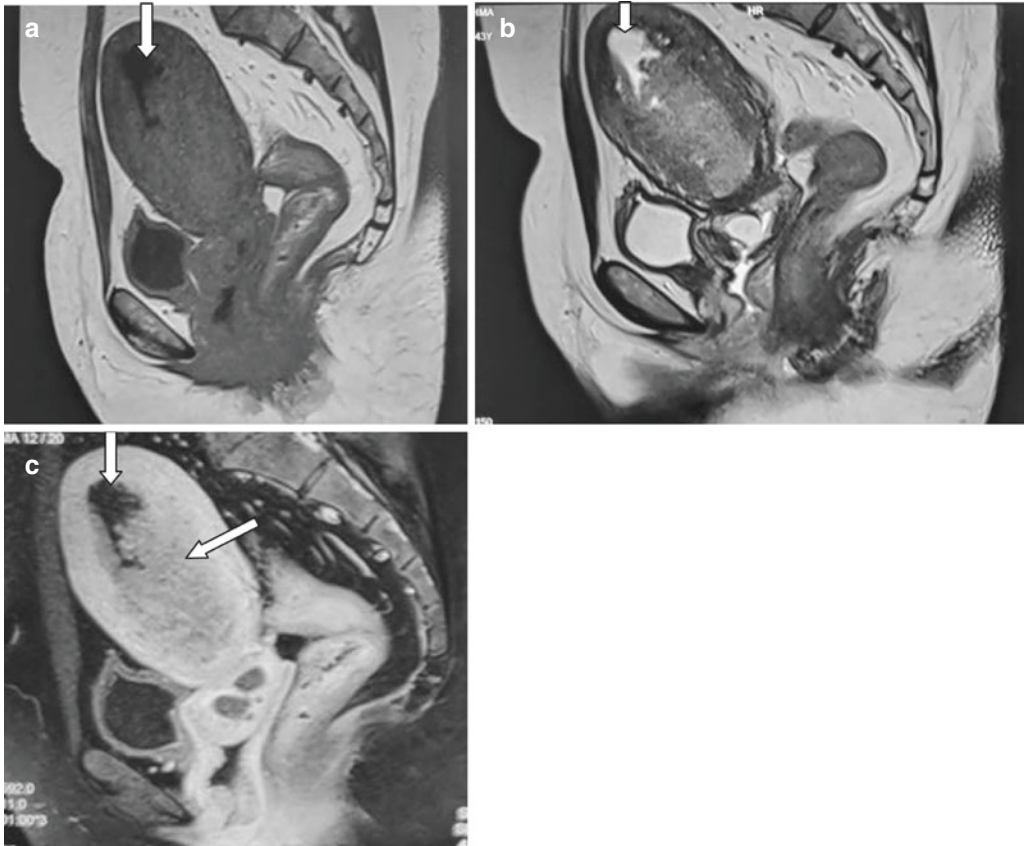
Endometrial cancer. (a–c) Sagittal T1, T2 and T1 contrast MR images of the pelvis showing an enhancing endometrial mass with loss of junctional zone (oblique
